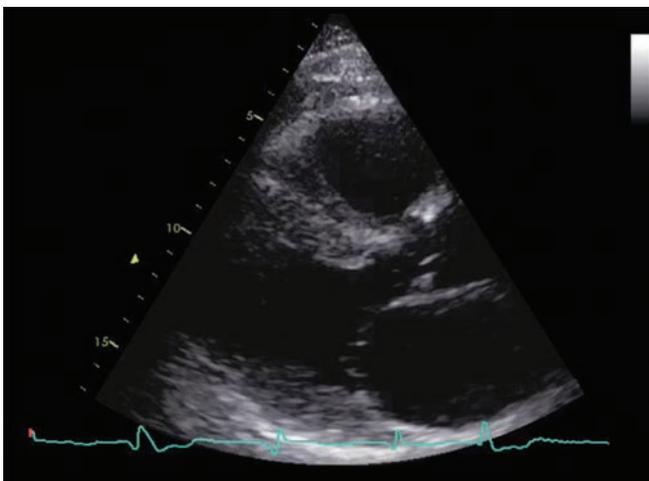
2D TTE. Parasternal long axis view of a 73-year-old active, mildly symptomatic male showing hypertrophied left ventricle.
